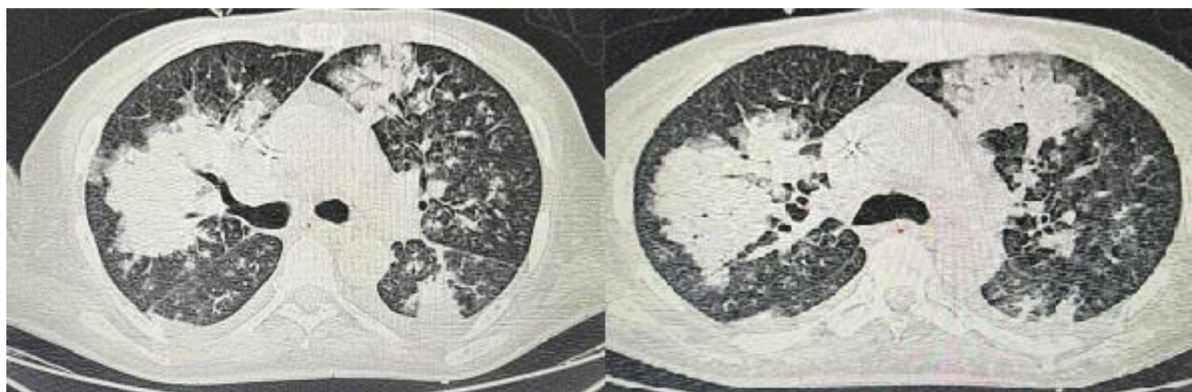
Chest CT scan on the first day of admission revealing bronchopneumonia with bilateral pleurisy.
